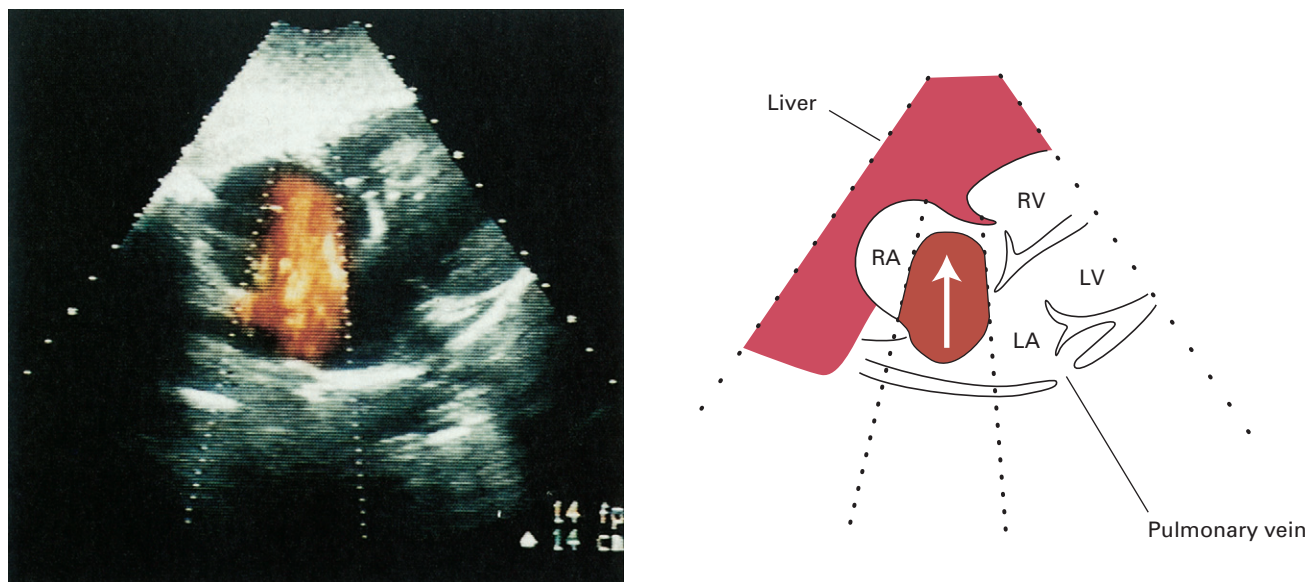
Atrial septal defect. Colour flow Doppler in the subcostal four-chamber view showing substantial flow (red) passing from the left to right atrium. LA, left atrium; LV, left ventricle; RA, right atrium; RV, right ventricle.
